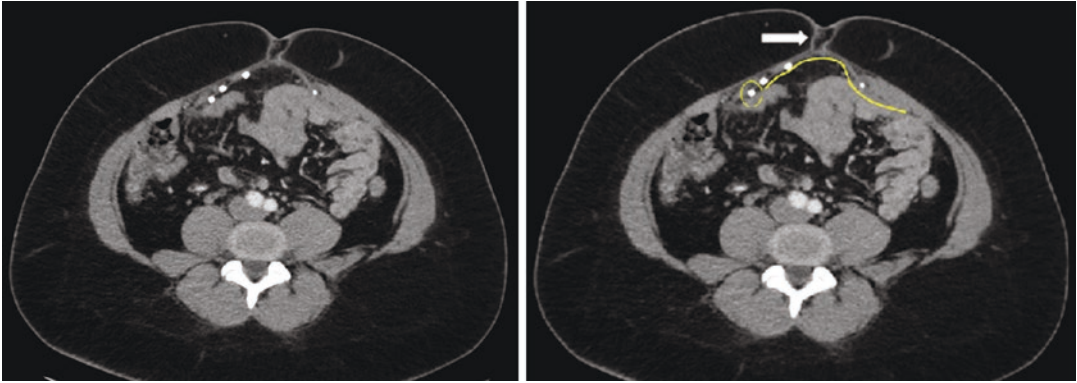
A 30-year-old patient referred by her primary care provider for “recurrent” umbilical hernia after prior laparoscopic ventral hernia repair. The patient reported a nonreducible bulge at her umbilicus. CT imaging was obtained and interpreted as recurrent ventral hernia. On further review of the imaging, the patient’s mesh repair and tacks were intact (yellow line and circle). Comparing with preoperative imaging, it was determined the patient
